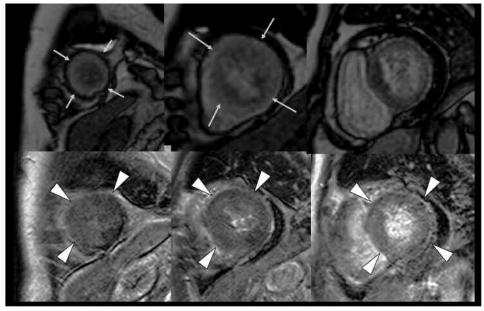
This case shows nonsegmental perfusion defect with diffuse delayed enhancement. A. Stress perfusion MRI shows circumferential subendocardial perfusion defect (arrows). B. Delayed enhanced imaging shows diffuse and faint enhancement (arrowheads).
